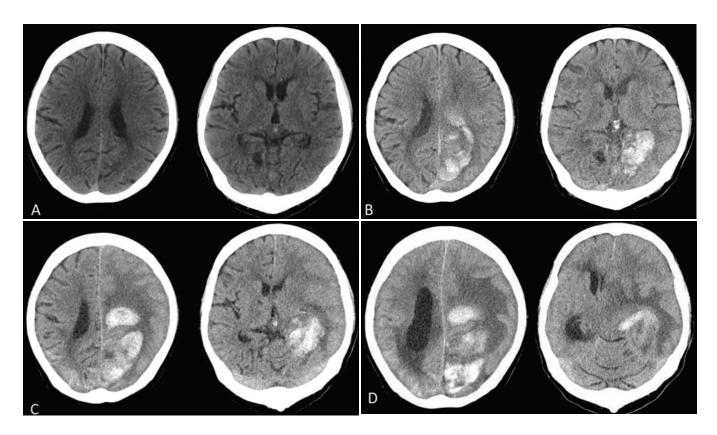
Computed tomography of brain at (A) pre-thrombolysis, (B) 8 hours post-thrombolysis, (C) day 9 and (D) day 16 of admission.
